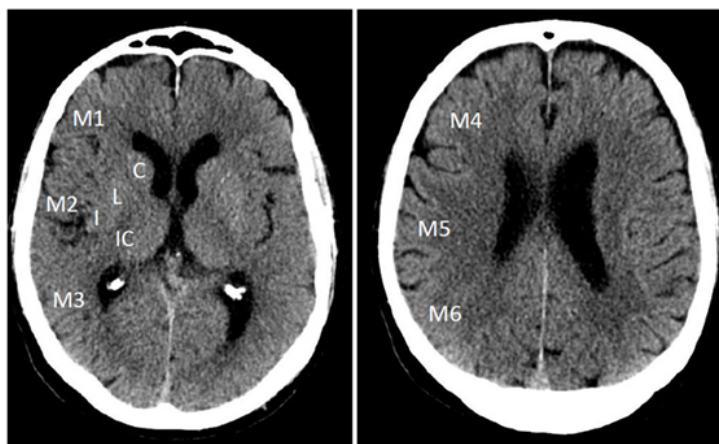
Representation of the 10 defined regions of the MCA on a NCCT for the calculation of ASPECTS. Source: Image taken from [13].
